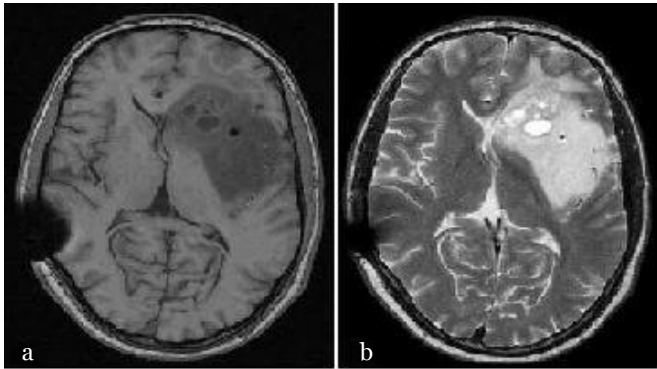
MRI of an *Oligodendroglioma*. (a) T1-weighted, and (b) T2-weighted imaging.
